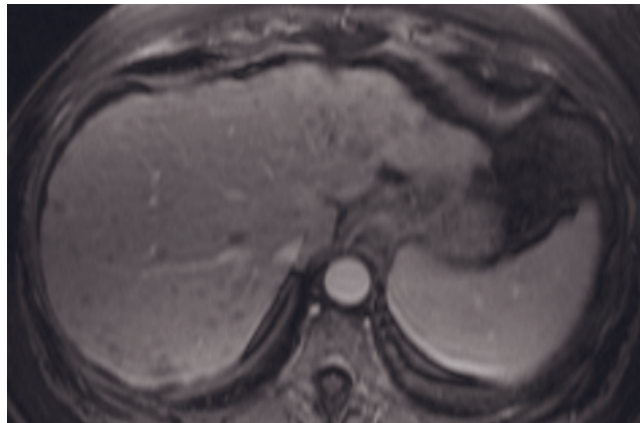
Liver metastases, chronic (11 years) after chemotherapy treatment. T2-weighted fat-suppressed ETSE (a) and immediate postgadolinium SGE (b) images. A 7-mm lesion is present in the right lobe of the liver that is minimally hyperintense on the T2-weighted image (arrow, a) and demonstrates negligible enhancement on the immediate postgadolinium SGE image (arrow, b).
